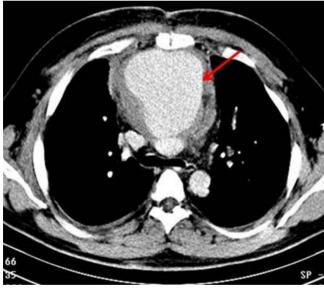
Contrasted helical CT scan showing an aneurysmal area at the level of the ascending aorta (arrow).
